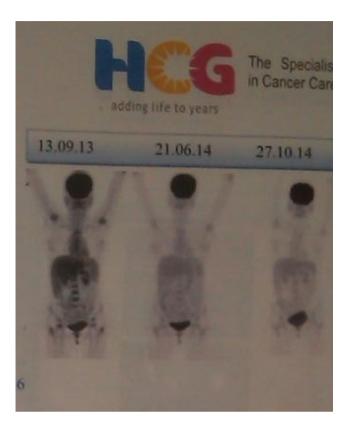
A comparative study of the PET–CT scans of the patient (a) after the first sequence of chemotherapy, (b) before surgery, and (c) after surgery and the second-line chemotherapy.
